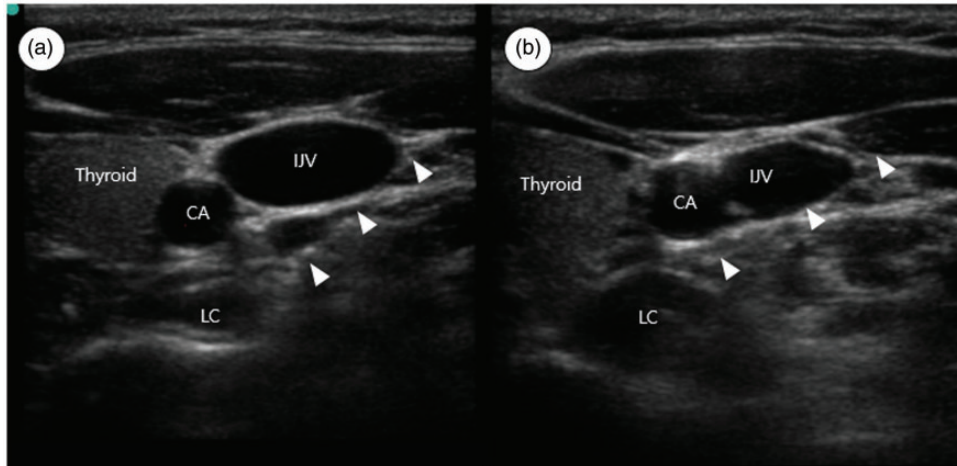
Ultrasound imaging at the time of botulinum toxin injection. The needle path is toward the fascia on the longus colli muscle. (a) Immediately below the left C6 anterior tubercle level. (b) Right C7 root level. CA, carotid artery; LC, longus colli muscle; IJV, internal jugular vein. The white arrowheads indicate the needle.
